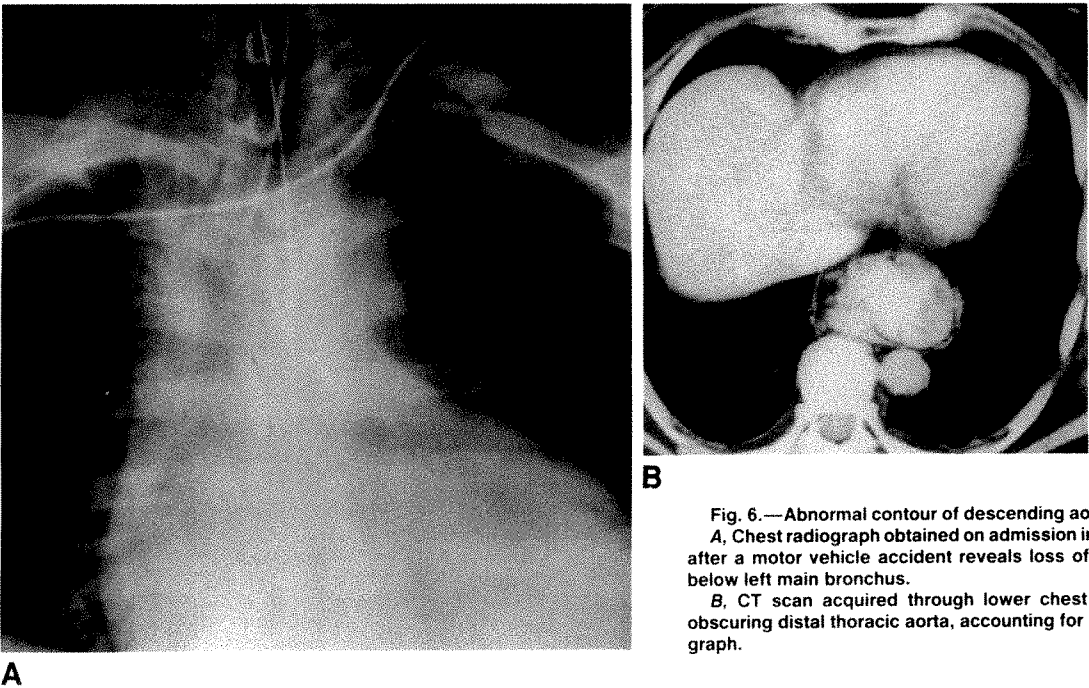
Abnormal contour of descending aorta created by hiatal hernia. A, Chest radiograph obtained on admission in supine 59-year-old woman after a motor vehicle accident reveals loss of descending aortic contour below left main bronchus. B, CT scan acquired through lower chest shows large hiatal hernia obscuring distal thoracic aorta, accounting for appearance on chest radiograph.
